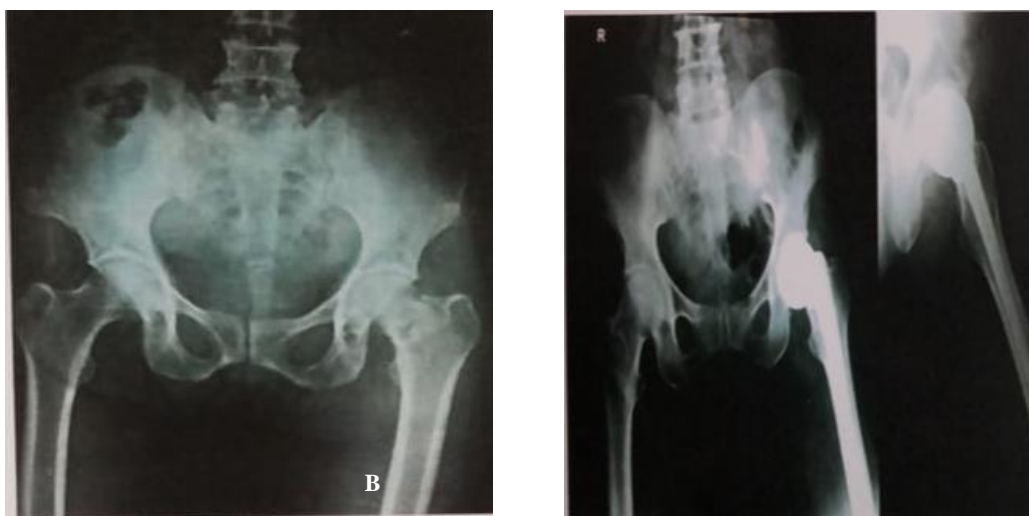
(A and B) Preoperative and follow-up X-ray (AMP case).
